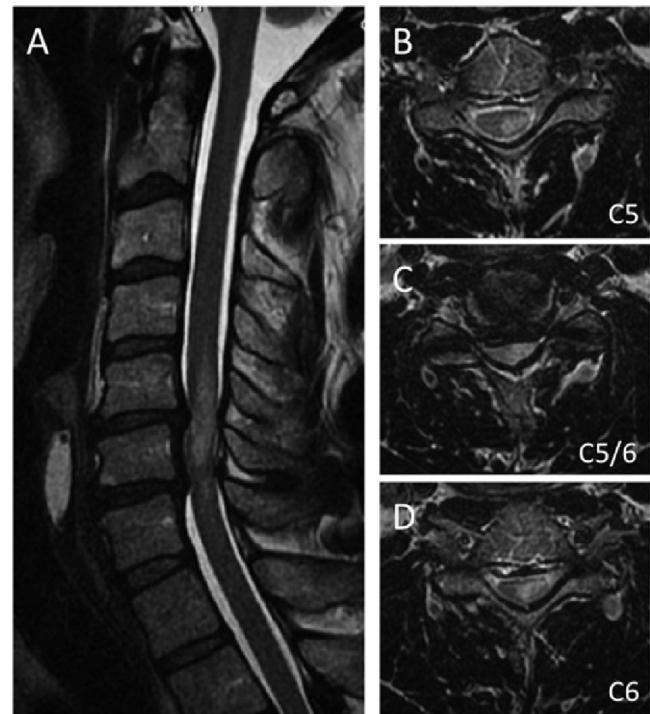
Cervical magnetic resonance (MR) images before rapid deterioration. (A) Sagittal images demonstrate both anterior and posterior indentations at C5/C6 and C6/C7 levels as well as the T2-weighted high-signal intensity area. (B–D) Axial images show circumferential effacement of subarachnoid space at C5/C6 and T2-weighted high-signal intensity area at the left side of cord.
